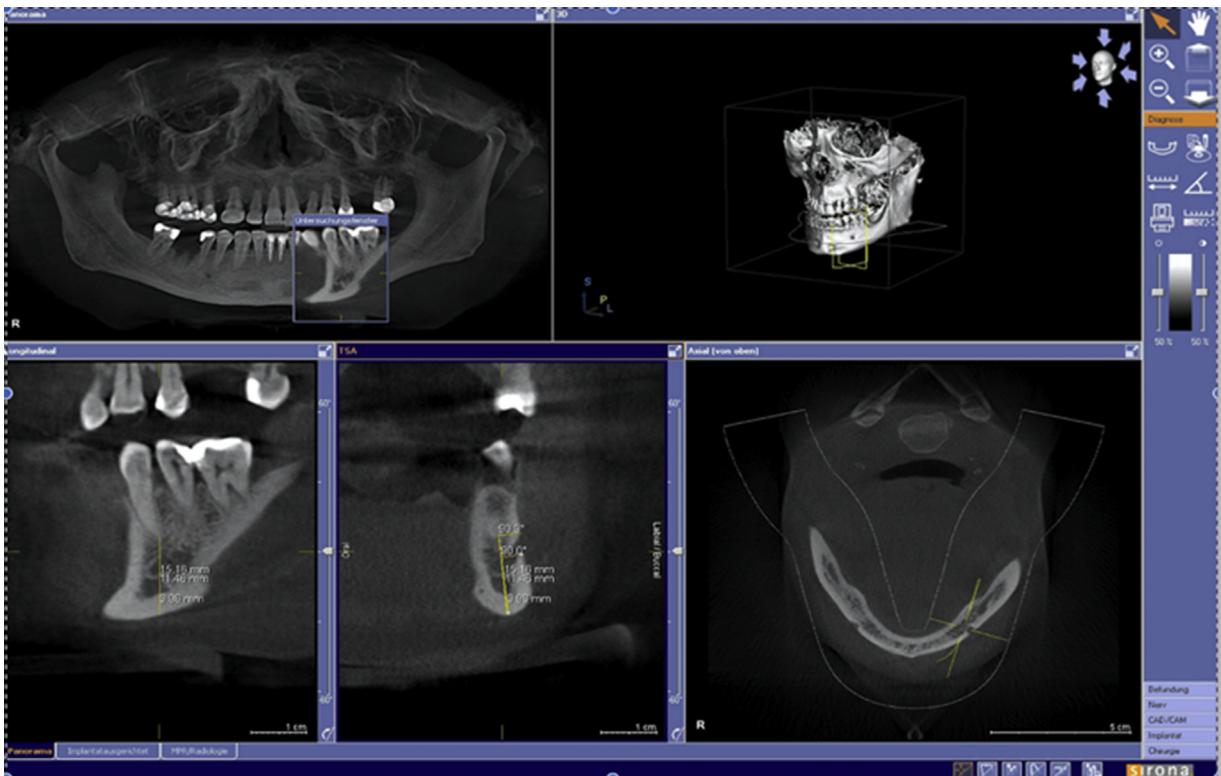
Assessment of CT Mental Index (CTMI) by morphometric analysis of the mandible.
